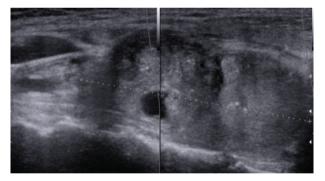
Ultrasonographic appearance of parathyroid carcinoma demonstrating inhomogeneous, lobulated, isoechogenic structure with cystic changes.
